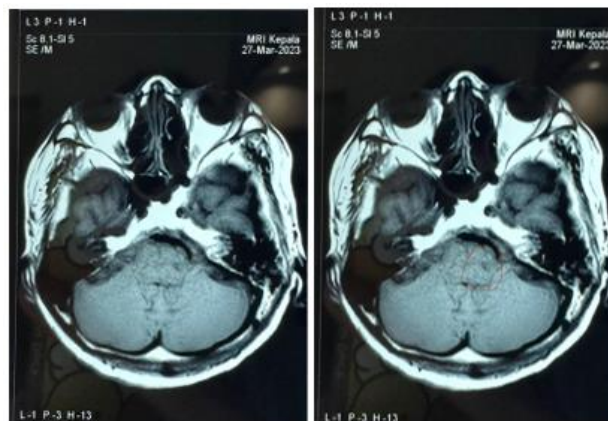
Diagnostic tests for the second patient. results of non-contrast MRI examination for the patient.
